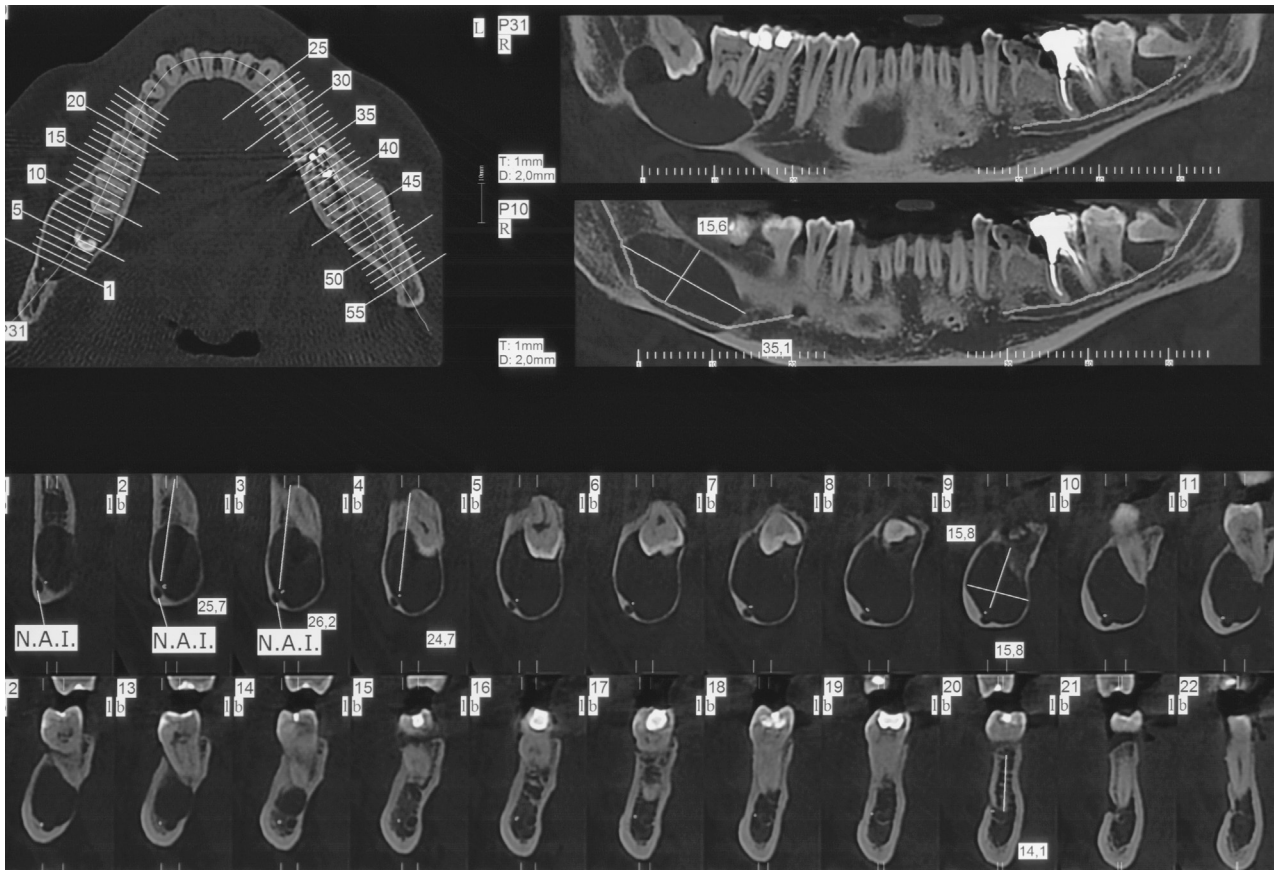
Cone-beam computed tomography cross-sectional slices before marsupialization showing a dentigerous cyst in the right mandible. *Consolo et al. Marsupialization of Mandibular Cysts. J Oral Maxillofac Surg 2020.*
